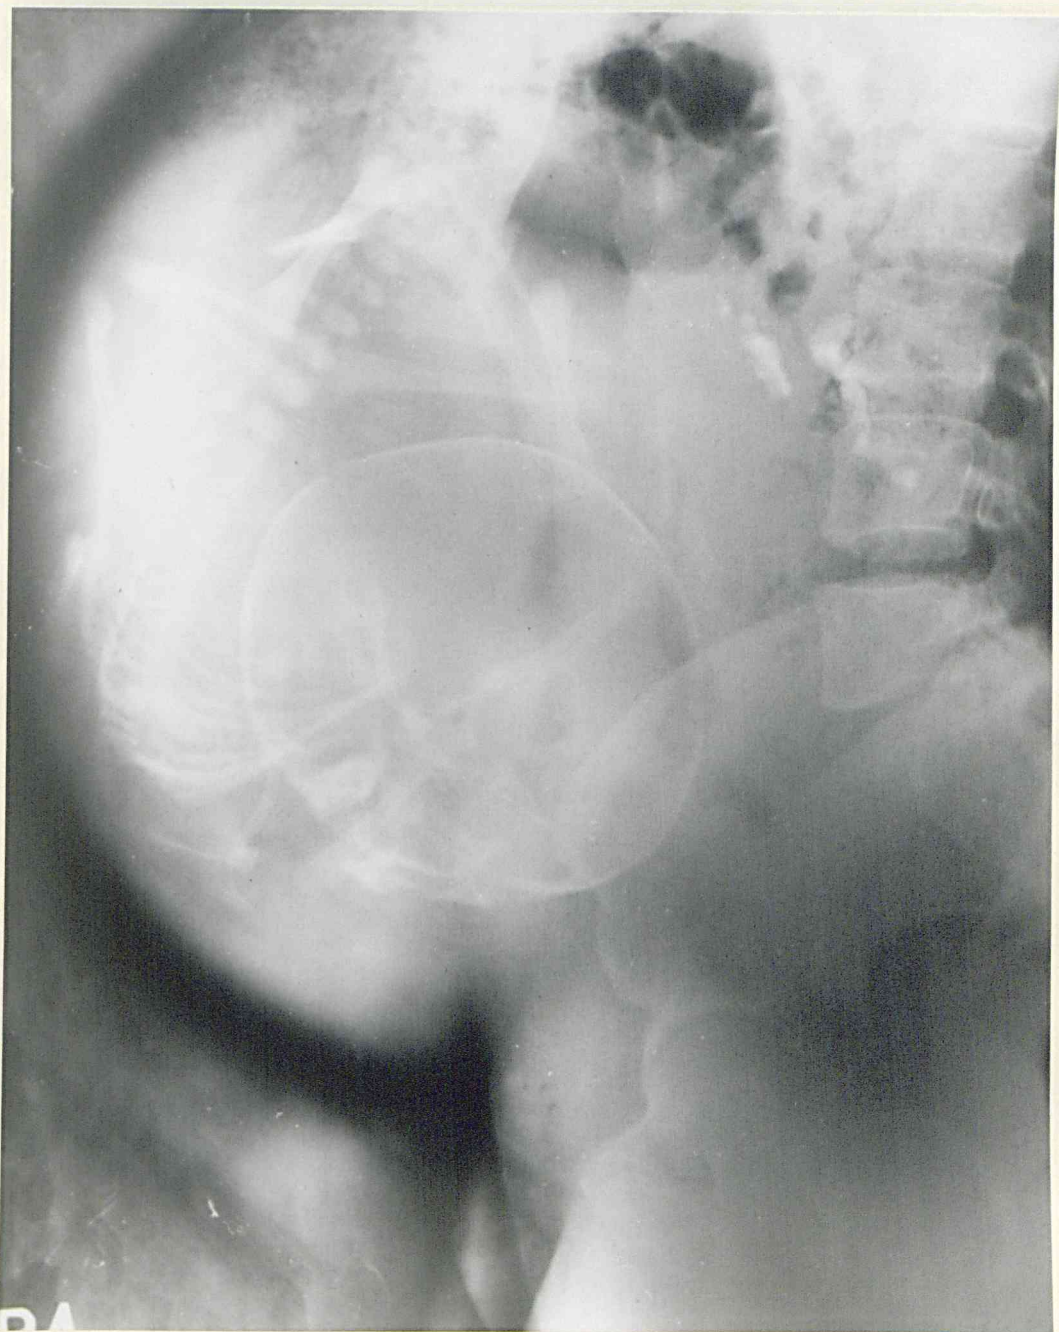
Lateral radiograph of the abdomen in a case of posterior placenta praevia. The foetus is lying transversely. The "placental shadow" is shown to be very low on the posterior uterine wall. The same case as Figure 62.
